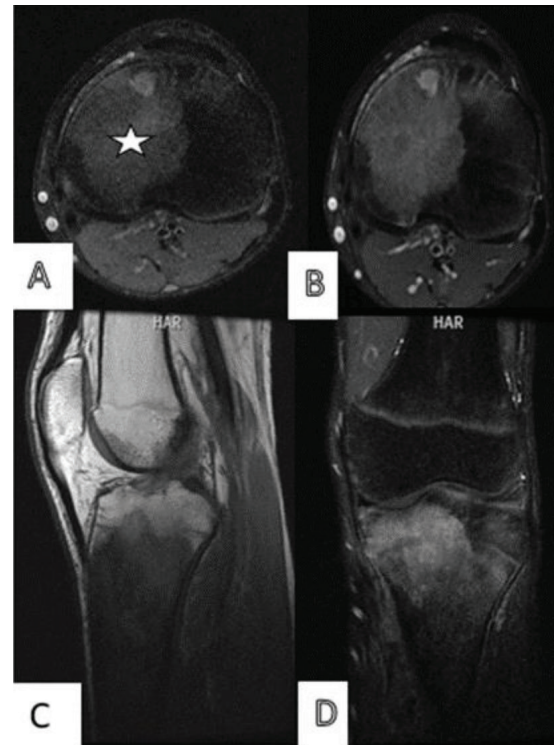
Chondroblastic osteosarcoma: A – axial T1-weighted fast spin echo magnetic resonance image of the tibia showing a lobular isointense morphology to the tumor (Stars); B – axial postcontrast T1-weighted magnetic resonance imaging displaying significant contrast enhancement; C – sagittal T1-weighted magnetic resonance imaging showing a lobular hypointense intramedullary component; D – hyperintense lesion extending to the epiphysis at coronal T2 weighted fast spin echo image
